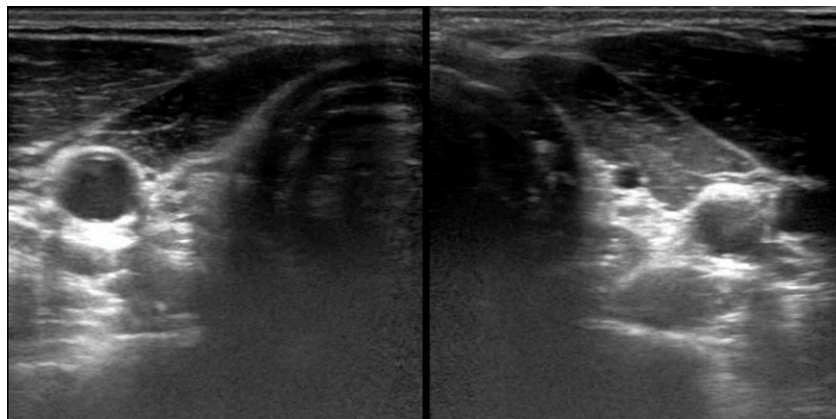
Cervical ultrasound showing complete agenesis of the thyroid.
